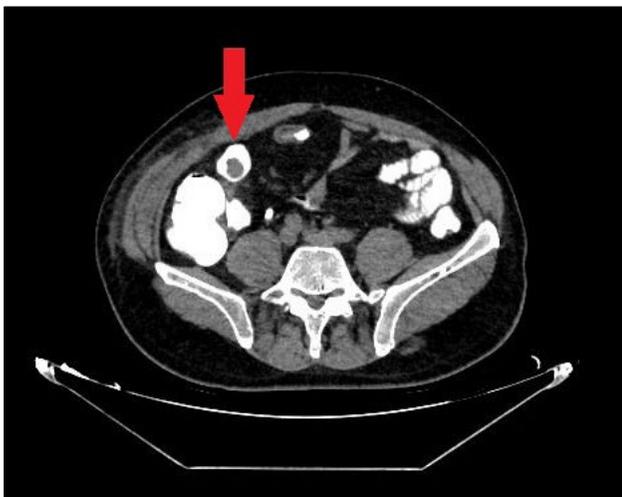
Ileal polypoid lesion, as seen on CT (arrow).
